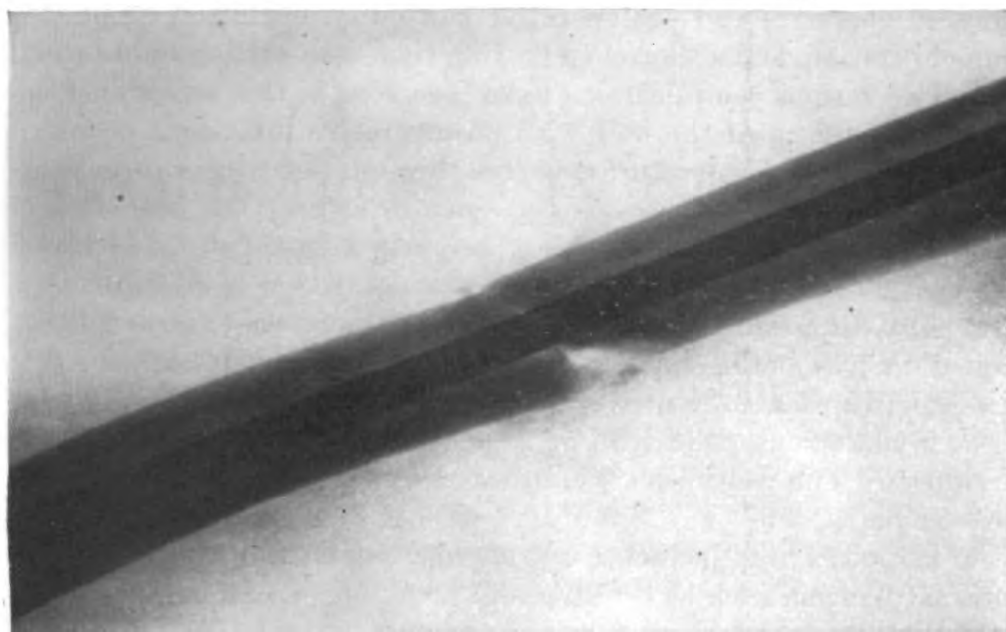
Case 6. Postoperative anterior-posterior x-ray.
